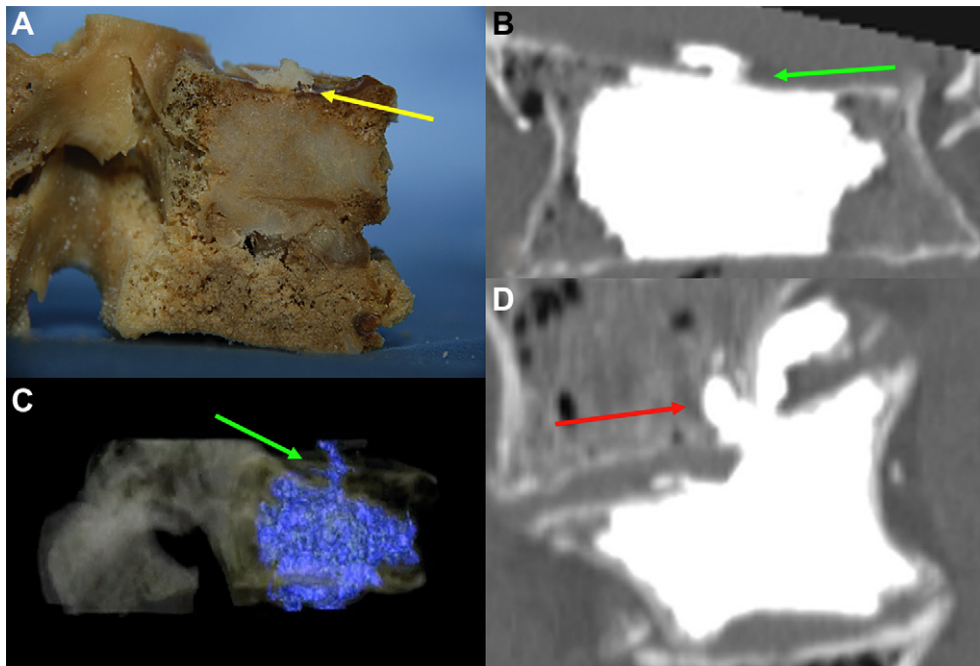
Cement leakage through the endplates. (A) Photograph of leakage (yellow arrow) through the end plates. (B) Computed tomography (CT) image of leakage into the disc space (green arrow). (C) Three-dimensional reconstruction of cement-filling pattern and leakage (green arrow). (D) CT coronal image of cement leakage through the end plate into the adjacent vertebra (red arrow).
